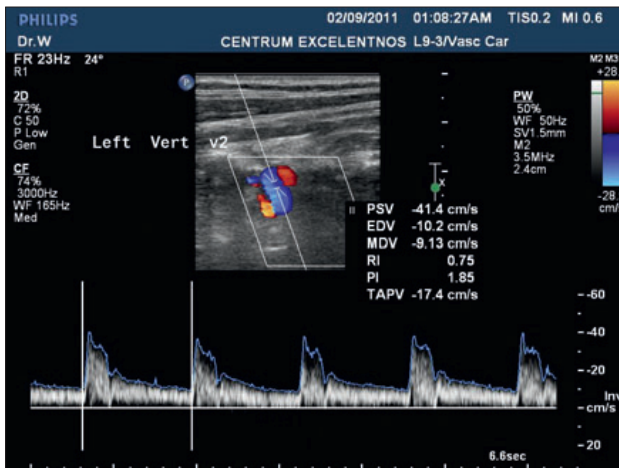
Left vertebral artery – V2 section, Colour coded doppler mode (CCDM).
